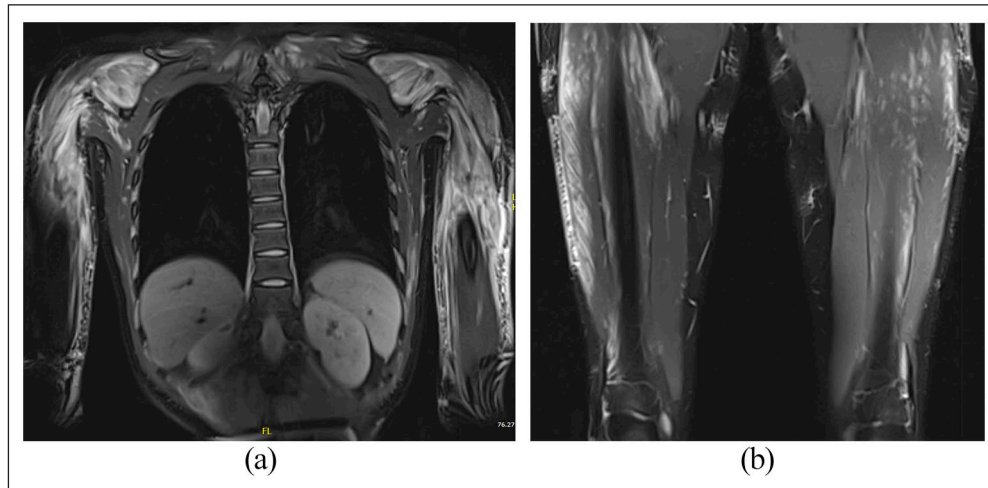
Magnetic resonance imaging demonstrates diffuse extensive patchy hyperintense T2 signal intensity seen in multiple muscles of the shoulders, upper arms, chest wall, abdominal wall, bilateral paraspinal regions (a), bilateral psoas, and bilateral thighs (b), keeping with myositis.
